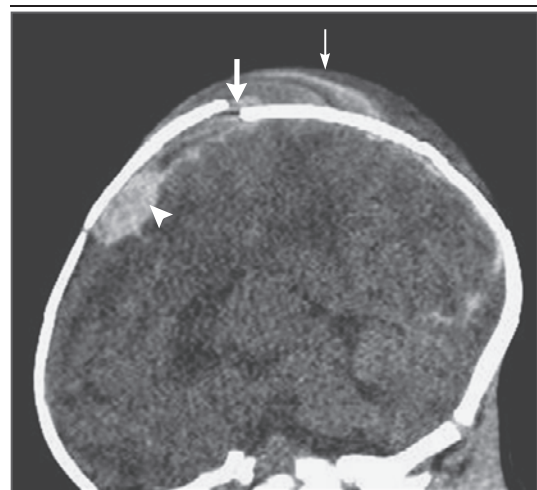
CT Scan of the Head of a 17-Day-Old Infant with a History of Fussiness.
